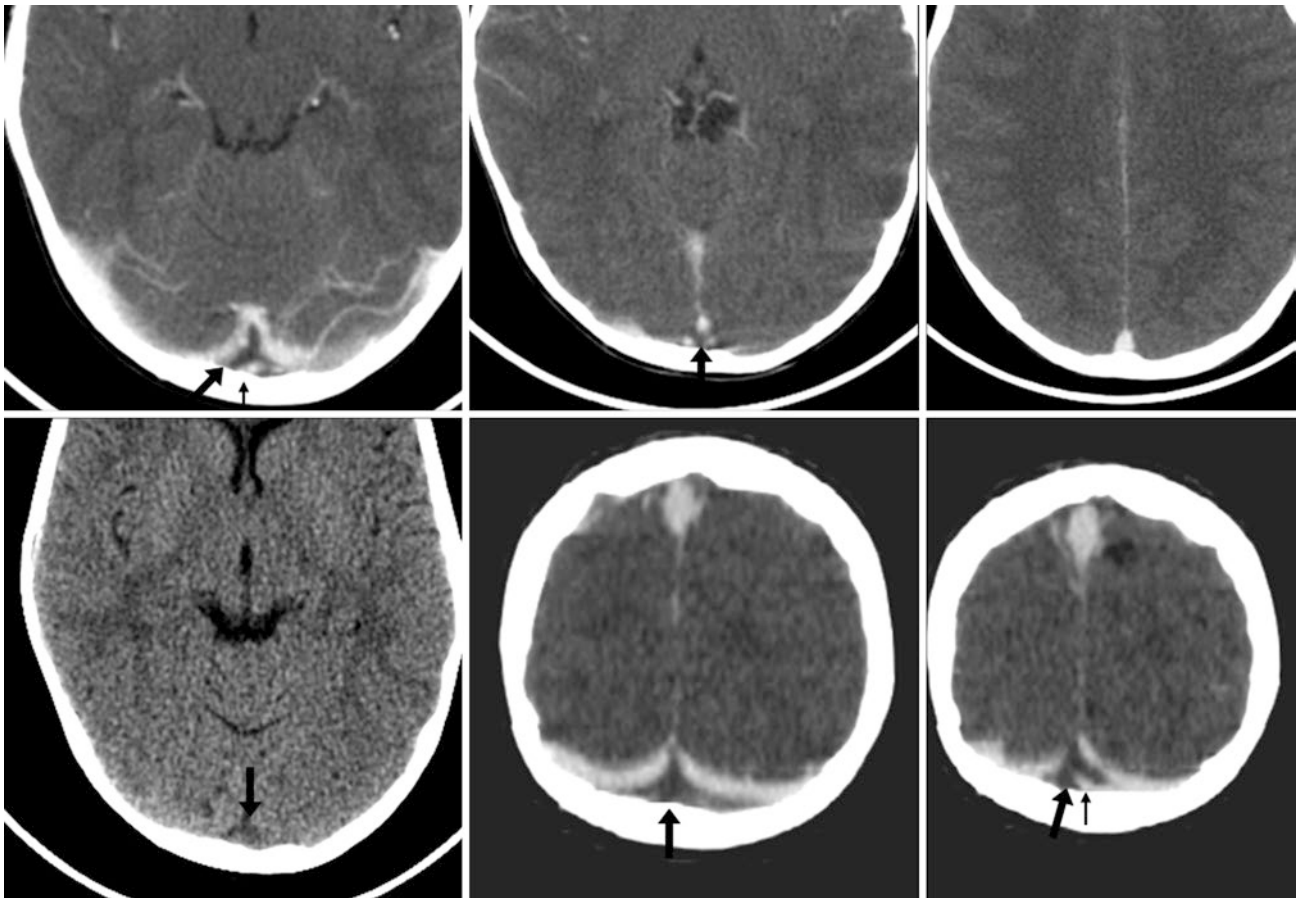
Dorsal SSS “split.” *Top row:* In this 3-year-old, axial contrast-enhanced CT images showed a torcular defect (*arrows*) that mimicked thrombus. *Bottom row:* The lack of hyperdensity on non-enhanced CT (*left*) excluded acute thrombus, and coronal MPRs (*middle and right*) showed this to be a normal split/fenestration, with a tiny transverse communicating channel (*thin arrows*)
